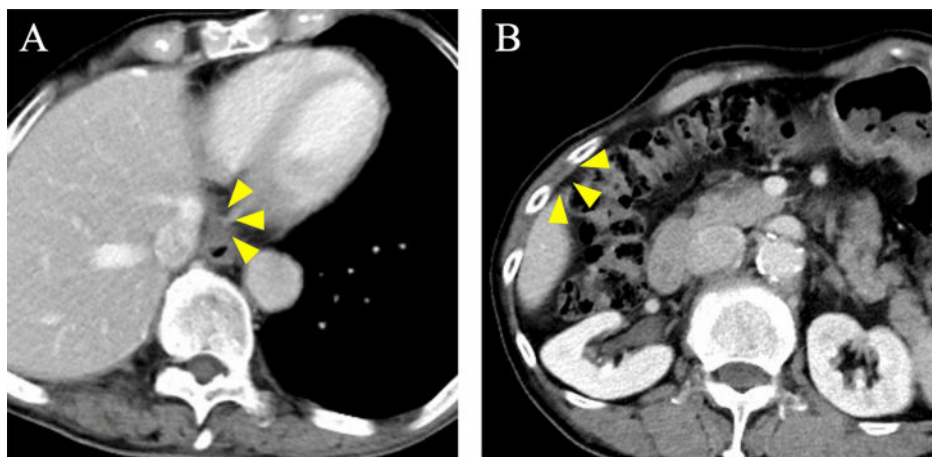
Chest computed tomography (CT) findings after nivolumab therapy.
